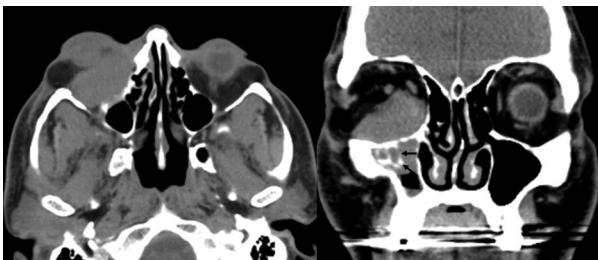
Axial (left) and coronal (right) CT. Coronal image demonstrates calcification (arrows) within the maxillary sinus component of the lesion.
